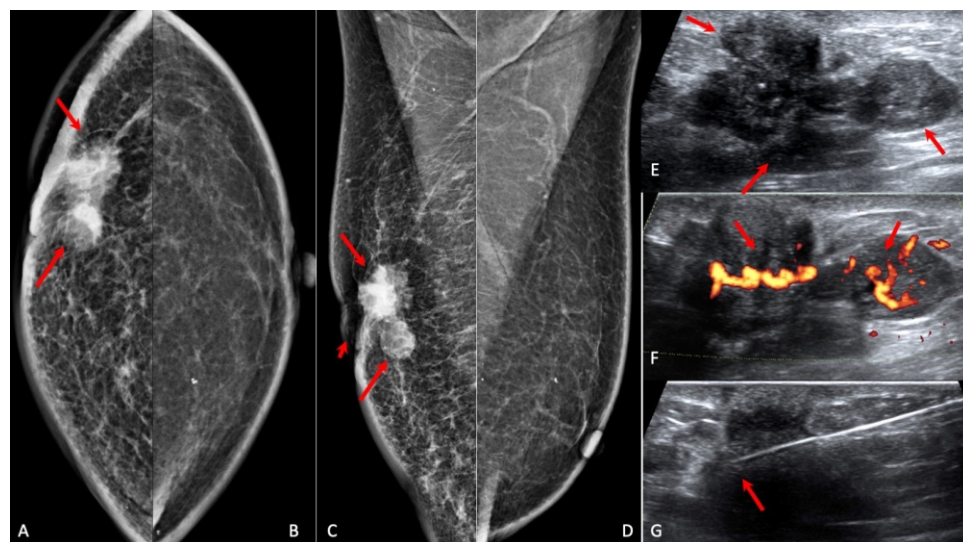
(A-G): Cancer: 82-years old man came with a painless lump in the right breast for a few months, increasing in size. The right CC (A), left CC (B), right MLO (C) and left MLO (D) images show an irregular, partly circumscribed and partly indistinct, eccentric mass in the right upper outer quadrant (arrows) with skin thickening and nipple retraction (arrowhead). USG (E) shows an irregular hypoechoic mass in the right retroareolar region at 10 o'clock position (arrows) with significant internal vascularity (arrows) on power Doppler (F). USG guided core biopsy (G) showed invasive duct carcinoma, grade II: ER positive, PR positive, HER2neu negative and Androgen receptor positive.
